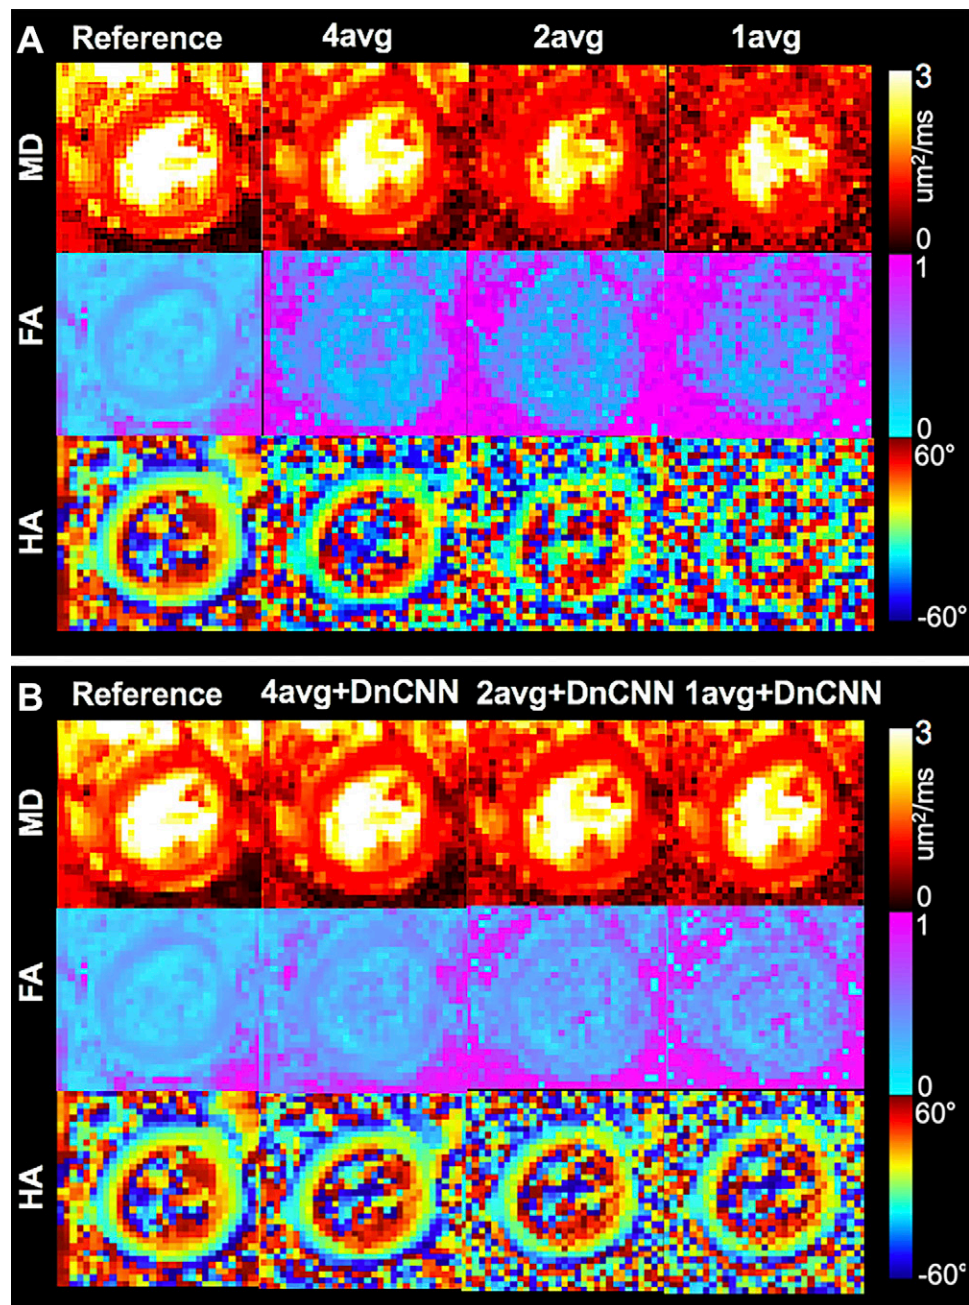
(A) Representative diffusion-tensor MRI (DT-MRI) parameter maps (mean diffusivity [MD], fractional anisotropy [FA], and helix angle transmurality [HAT]) comparing four-, two-, and one-average (avg) data with reference eight-average data. (B) Representative DT-MRI parameter maps (MD, FA, HA) comparing DnCNN-denoised four-, two-, and one-average data with the reference eight-average data.
